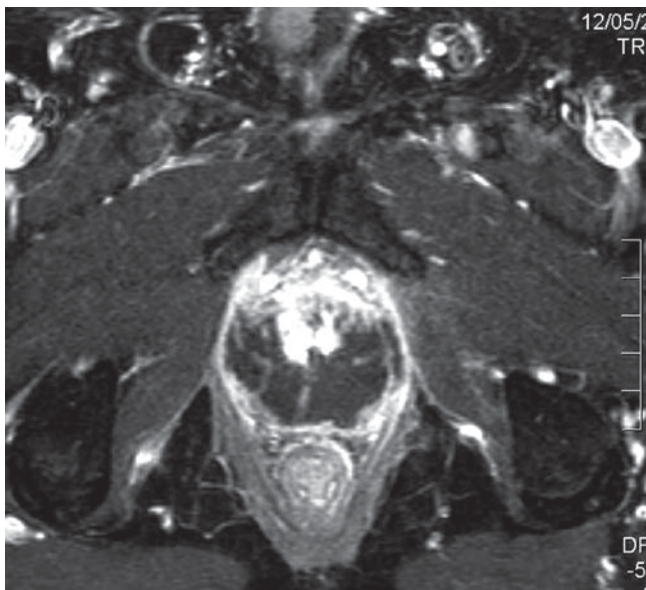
Post-HIFU (Sonablate 500) dynamic contrast enhanced MRI in a different patient demonstrating viable tissue in the anterior region of the prostate as demonstrated by enhancement. Residual prostate cancer and a PSA >0.5 ng/mL was demonstrated at 6 months
